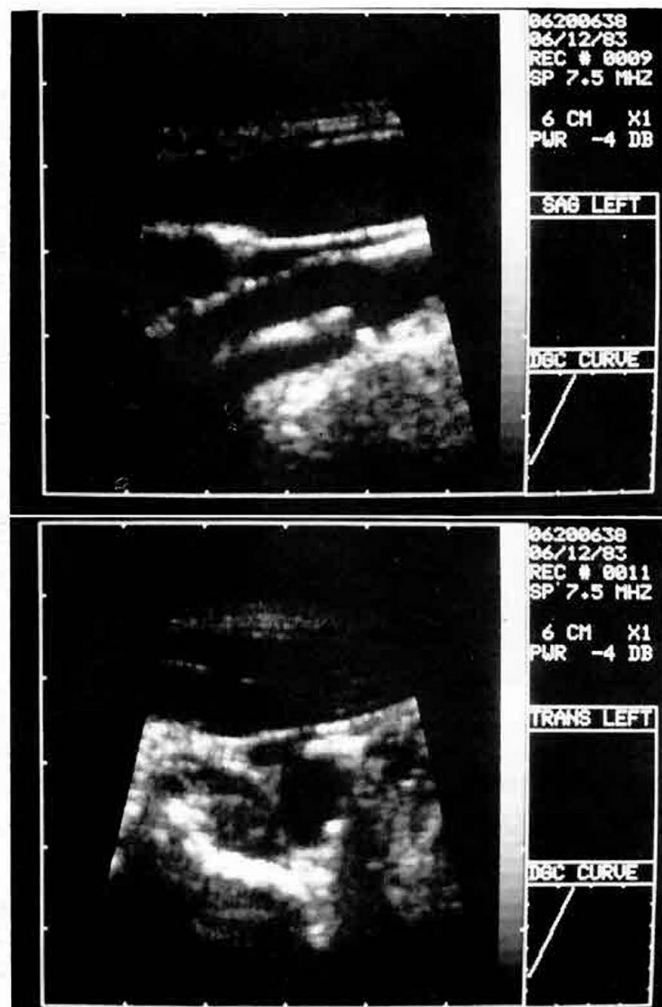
Sagittal and transverse 7.5MHz ultrasound image of the left carotid artery bifurcation with duplex pulsed Doppler ultrasound display showing an atherosclerotic plaque.
